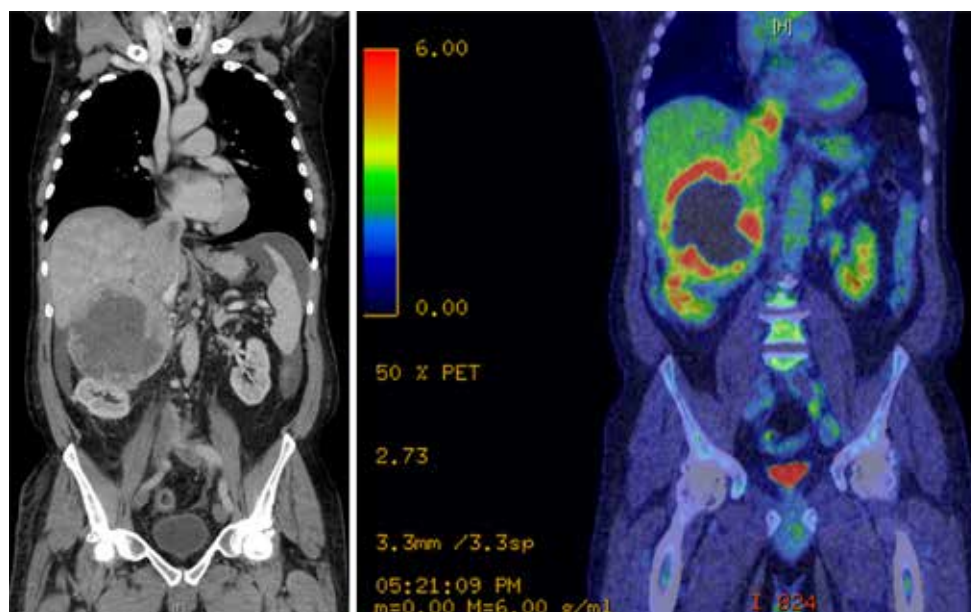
Radiological findings of patients with level IV tumour thrombus. Pheochromocytoma invading the IVC demonstrated on CT scan and confirmed on PET scan. IVC, inferior vena cava.
